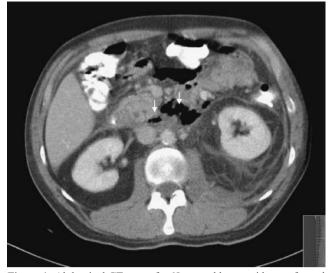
Abdominal CT scan of a 68-year-old man with a perforated duodenal diverticulum. The scan shows extraluminal retroperitoneal air around the ascending duodenal segment (segment IV) (*white arrows*) as well as minimal retroperitoneal, pararenal fluid with an impressive fat stranding in a 68-year-old male patient with a perforated duodenal diverticulum.
